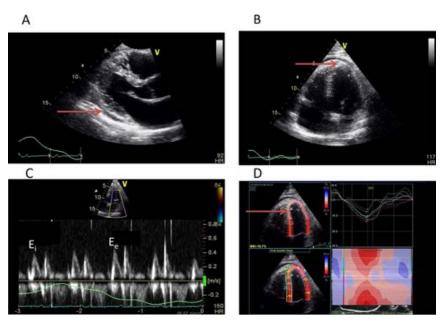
Characteristic two-dimensional echocardiographic findings in the parasternal long-axis view (A; Video 23; available at www.onlinejase.com) and apical four-chamber view (B; Video 24; available at www.onlinejase.com), Doppler findings from the mitral inflow with the E velocity in inspiration (E_i) and expiration (E_e) noted (C), and speckle-tracking (D) in a patient with effusive constriction. Note the thickened pericardium (*arrow*), respiratory variation in the mitral inflow, and decreased regional longitudinal strain. Reprinted with permission from Dahiya. ¹⁶⁰
